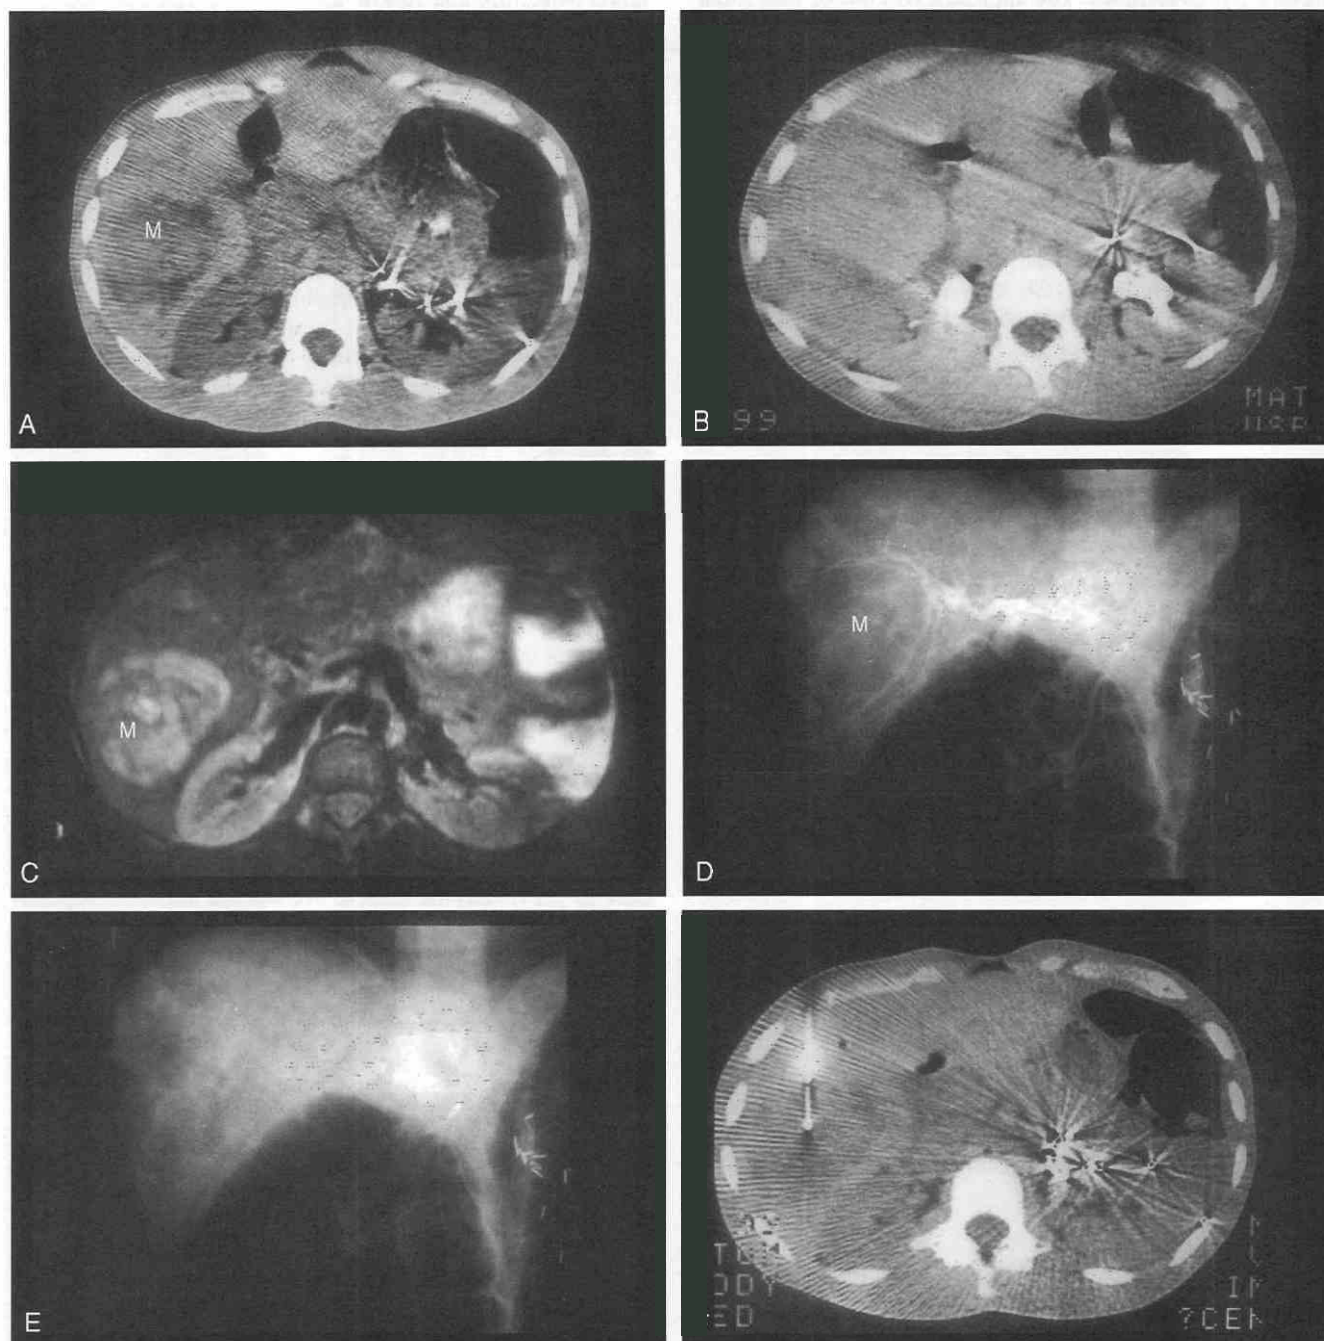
The definitive qualities of the bolus assessment of vascular lesions can be demonstrated by this highly unusual case. This series of scans (A to F) show the images of an "atypical hemangioma" that does not show the typical qualities. Such lesions are partially thrombosed and have very small capillaries so there is no significant increased blood flow perceptible. A, This scan shows a low-density mass (M) in the right lobe of the liver. B, Later scans did not show typical enhancement but did show homogeneous appearance in the late phase. C, T2-weighted image shows a large image with inhomogeneous intensity, not completely characteristic with hemangioma. D, Because there was still concern about hemangioma, an angiogram was performed. This early-phase image shows hepatic vasculature but no increased vascularity. E, Late-phase angiogram shows no evidence of "puddling," said to be characteristic of hemangioma. F, A 14-gauge biopsy of the lesion shows a gap centrally in the lesion. Pathology reports showed hemangioma. The point is not that biopsy should not be performed in hemangiomas but rather that the bolus study is so sensitive to blood flow that if a lesion is avascular with this method, one can perform a biopsy of an unknown mass with confidence that there will be no bleeding. Rarely, such avascular masses will ultimately prove to be atypical hemangiomas.
